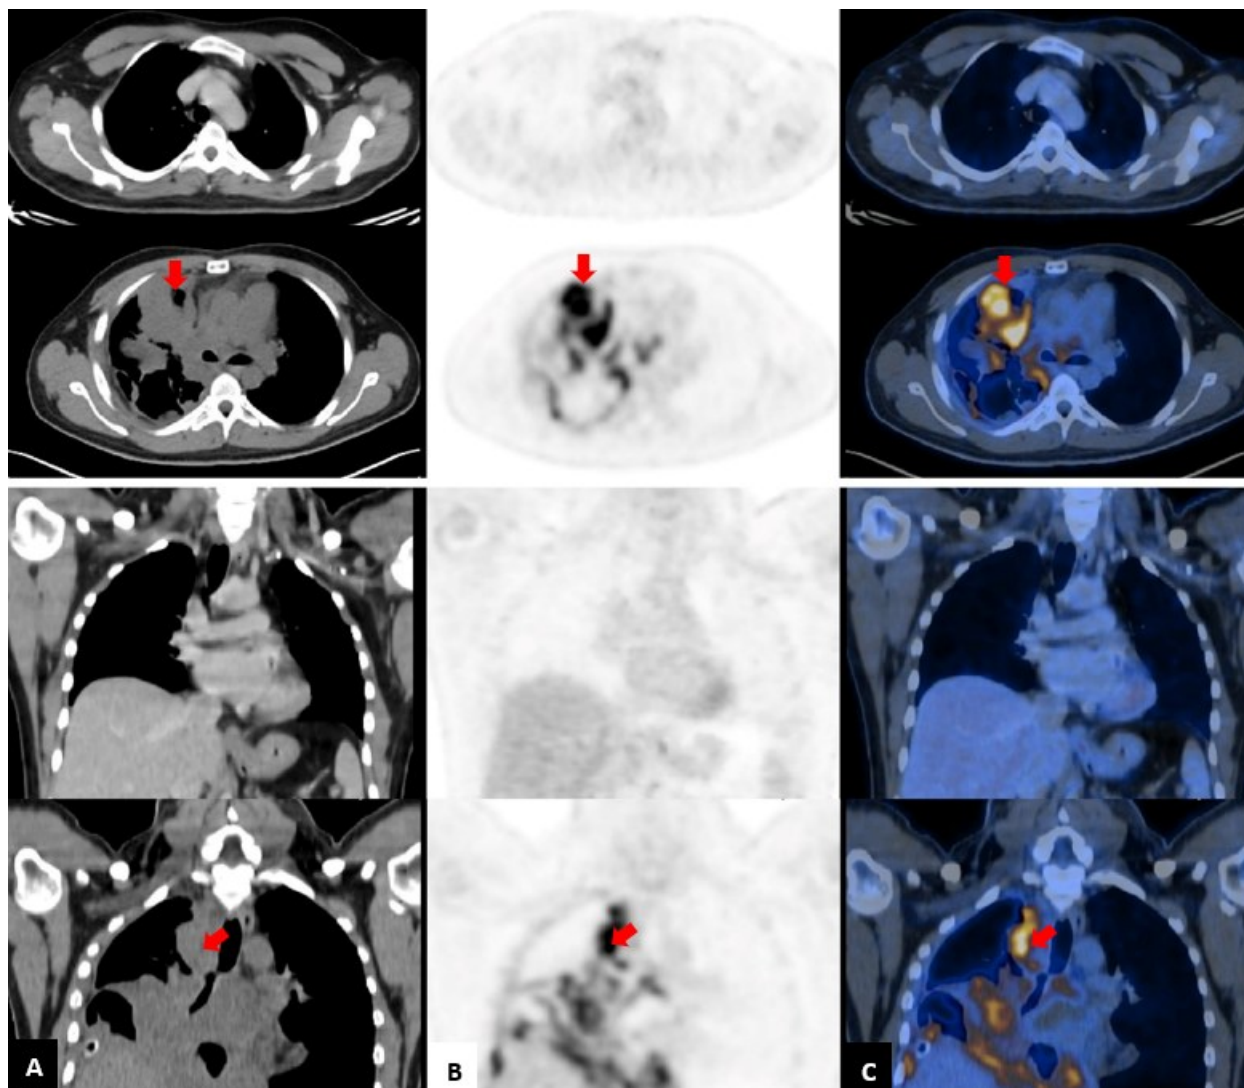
Axial view and coronal view showing the (A) CT, (B) PET, and (C) fused PET/CT images of the patient's third whole-body PET/CT scan showing the mass-like consolidation of the right upper and middle lobes (red arrow) with associated compression of adjacent structures. Previous PET/CT scan (1st row) and latest PET/CT scan (2nd row).
